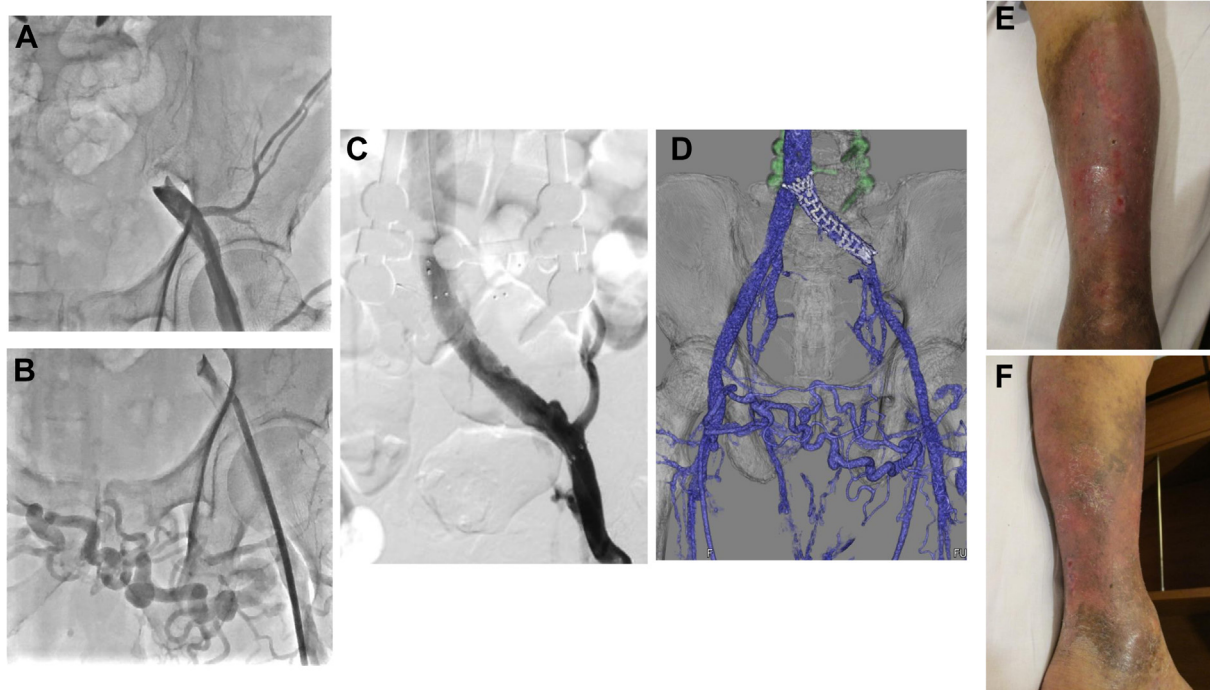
Operative and postoperative data of case 2. A, Venography before stenting showed occlusion of the left common iliac vein (CIV) with highly developed collateral vessels (B). C, Venous stenting (VS) was performed in the left CIV. The developed collateral vessels were undetectable. D, Computed tomography (CT) angiography three-dimensional reconstruction (venous phase) showing patent venous stent with decreased collaterals. E, and F, Healing of the skin ulcers after VS.
